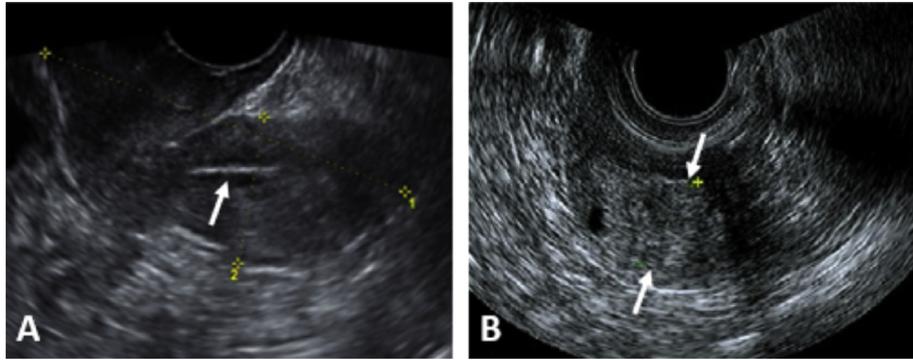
(A) Transvaginal ultrasonography of the endometrium at the pre-TVM evaluation. The arrow indicates a thin endometrium appearing as a white line. (B) Thirteen months after the TVM, the endometrial thickness, indicated by two arrows, was 20 mm. TVM = transvaginal mesh.
